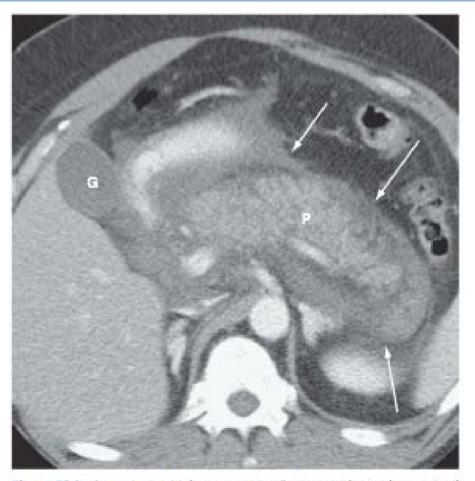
Acute interstitial pancreatitis. Contrast-enhanced computed tomography shows diffuse swelling of the pancreas (P) with peripancreatic inflammatory changes (arrows). The pancreas was well perfused without evidence of necrosis. G, gallbladder.
